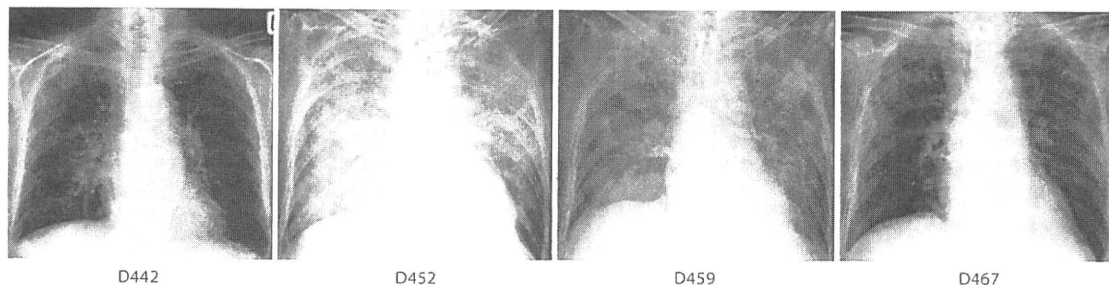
The chest X-rays on days 442, 452, 459 and 467 after allo-HSCT. On day 451, the patient was intubated for mechanical ventilation. On day 452, intravenous cyclophosphamide pulse therapy was given, at a total dose of 1 g per day for 2 consecutive days.
